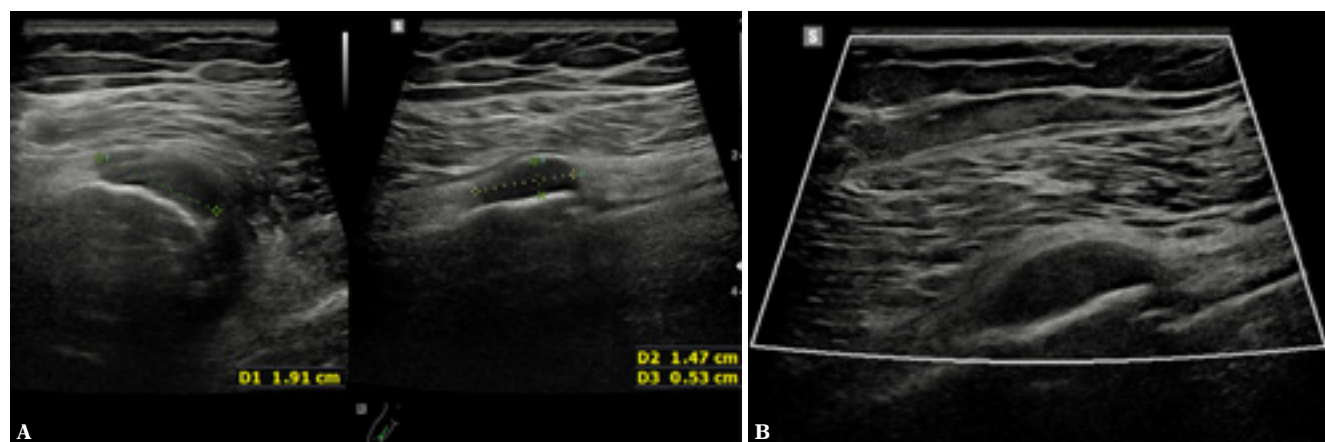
Ultrasound performed 3.5 years after the completion of oncological treatment. Hypoechoic lesion located at the border of the femoral stump and endoprosthesis (A), nonvascularized in the color Doppler US (B)
